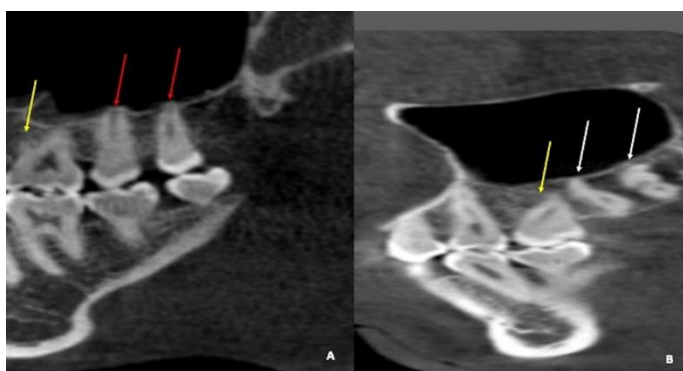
Representative CBCT images of the 3 types of relationships between maxillary posterior roots' apices and MSF in sagittal planes in A and B showing: Type TS (positive value, the root apex is touching the maxillary sinus floor) with the white arrows, Type IS (negative value, the root apex inside the MSF) with the red arrows, and Type OS (Positive value the root apex inside the MSF) with the yellow arrows
